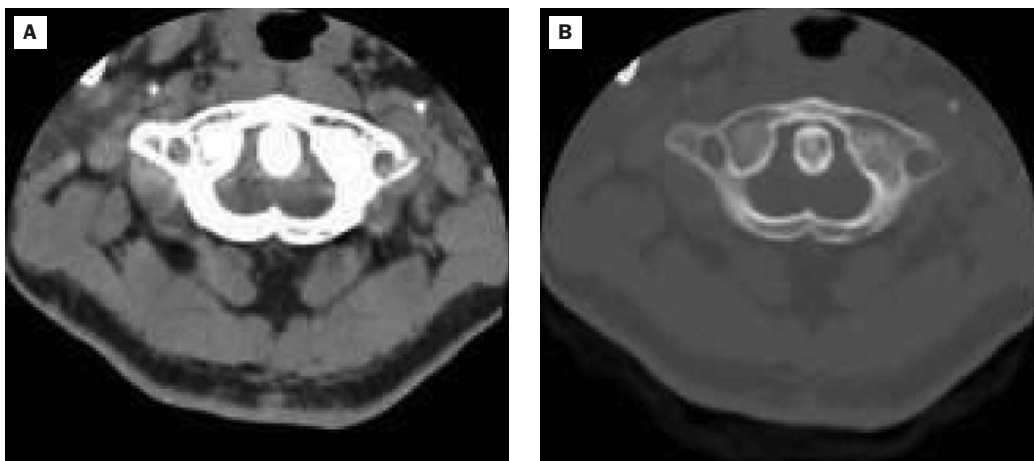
Cervical spinal computed tomography at the atlas level. Note the hypoplasia and incurving of the posterior arch, with ridge formation on the midline within the canal. The narrowest width of the canal is 12.46 mm.
